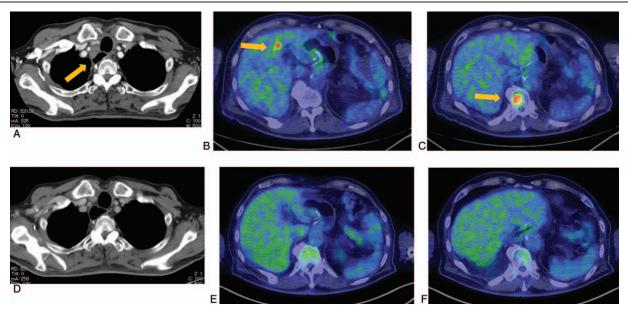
Computed tomography and fluorodeoxyglucose-positron emission tomography reveal mediastinal and supraclavicular lymph node (A), liver and bone metastases (B, C). Following 4 cycles of chemotherapy, supraclavicular lymph node (D), liver and bone metastases (E, F) disappeared.
